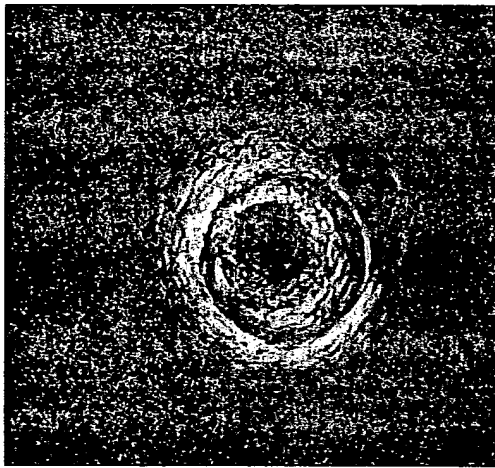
The Multilink stent can be easily and safely recrossed for intravascular ultrasound guidance. Here the final acute result of this case shows good apposition and a nicely circular lumen.
